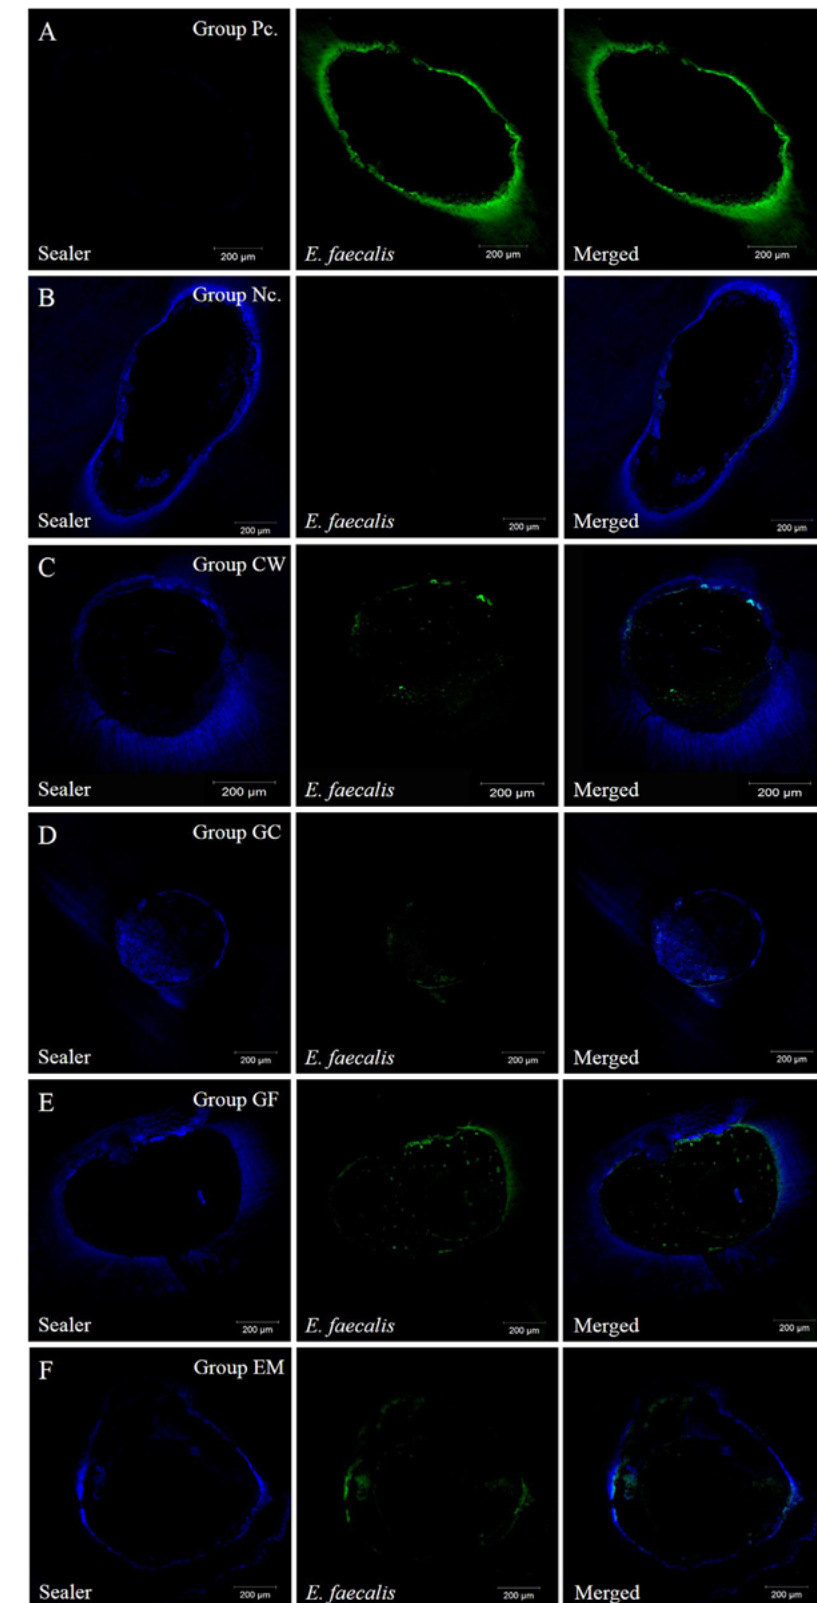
The representative CLSM results of control groups and experimental groups: A. Group Pc (Positive control). B. Group Nc (Negative control). C. Group CW (continuous wave of condensation technique with GP and AH Plus sealer). D. Group GC (GuttaCore system with AH Plus sealer). E. Group GF (GuttaFlow obturation system with GP). F. Group EM (Ultrasonic condensation with EndoSeal MTA and GP).
